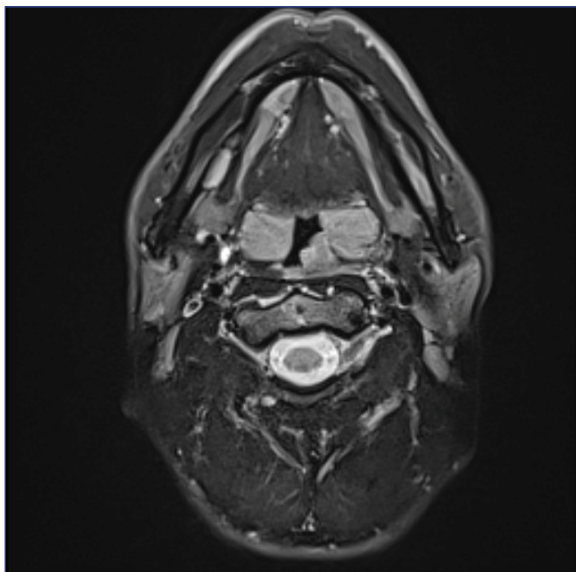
Axial section of an MRI scan of the head and neck showing an oropharyngeal lesion compatible with an oropharyngeal carcinoma.
